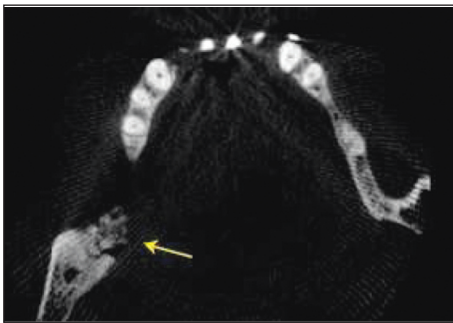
Axial computed tomography imaging showing the necrotic bone.
